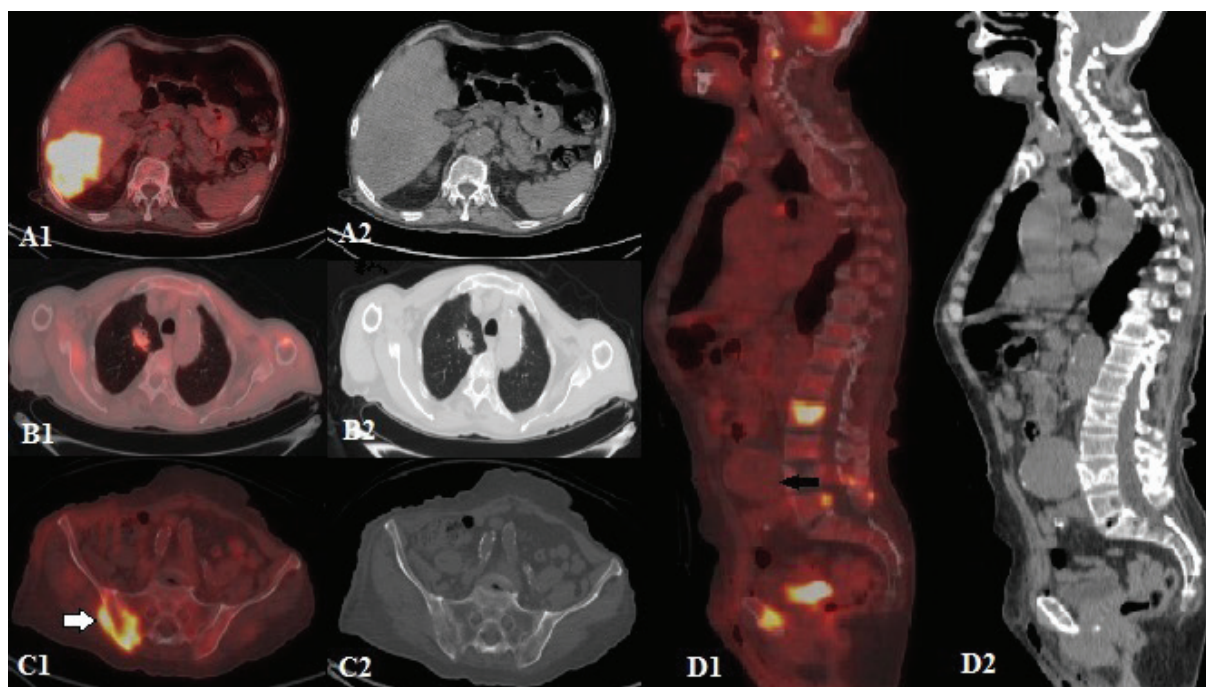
An F-18-fluorodeoxyglucose positron emission tomography/computed tomography was performed to identify the primary tumor site and revealed a mass lesion (86x74x120 mm) in the right lobe of the liver (SUV_{max}: 21.2) (A1, A2), an irregularly contoured right lung upper lobe anterior segment mass (27x35 mm, SUV_{max}: 4.6) (B1, B2), right hilar and subcarinal lymph nodes, and bone lesions in right iliac crest (SUV_{max}: 14.5) (C1, C2, white arrow) which were hypermetabolic, along with a hypometabolic giant abdominal aortic aneurysm (AAA) (65x92x79 mm) (D1, D2, black arrow). The patient did not have a history of trauma or infection, therefore the lesion was diagnosed as a true aneurysm. The patient was referred to cardiovascular surgery for surgical intervention and interventional radiology for liver biopsy
